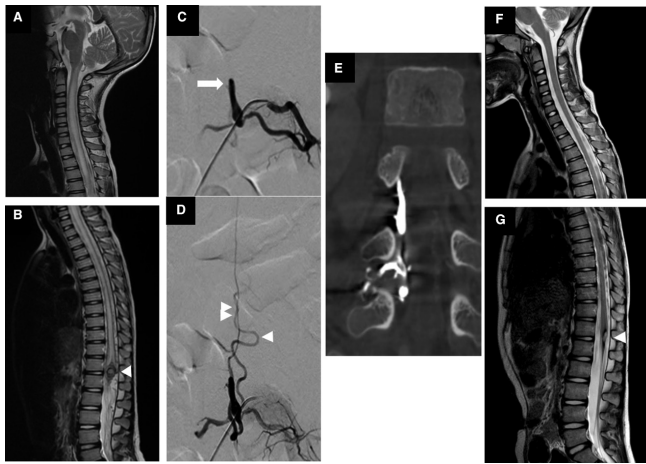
Example of spinal epidural arteriovenous fistula (AVF). (a–b) Pretreatment sagittal T2-weighted magnetic resonance image (MRI) of cervical and thoracolumbar spine shows hyperintense T2 cord signal change from craniocervical junction to conus medullaris with venous pouch at T12/L1 level (white arrowhead). (c) Early epidural venous pouch is fed by left L4 segmental artery (white arrow). (d) Epidural venous pouch drains into 2 radicular veins (white arrowhead). (e) Coronal reformatted image of flat panel computed tomography after transarterial glue embolization shows glue cast in venous pouch, confirming the position of venous pouch is in the epidural space. (f–g) Posttreatment sagittal T2-weighted MRI of cervical and thoracolumbar spine shows resolution of hyperintense T2 change of the spinal cord with hemosiderin deposit at the previously seen venous pouch (white arrowhead).
